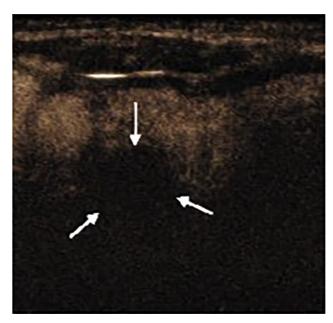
Contrast-enhanced ultrasound shows the whole mass with no enhancement continuously (arrows) 3 days after ablation.
